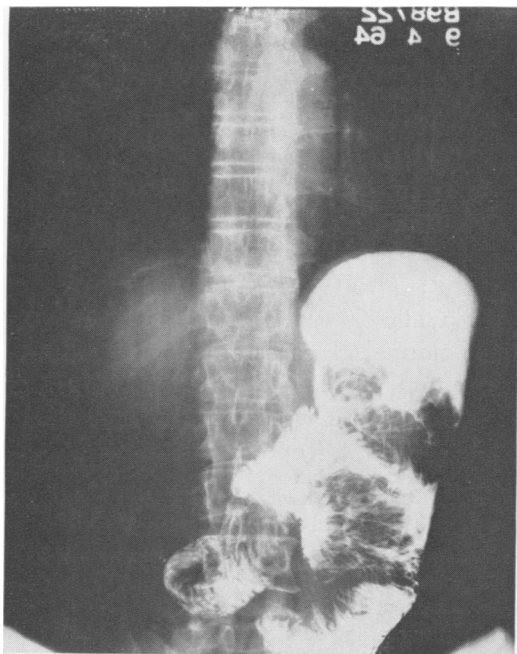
Radiograph demonstrating jejuno-gastric intussusception in Case 1.
